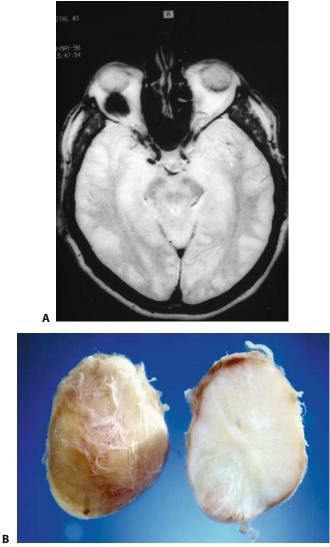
T2-weighted MR image of the orbit shows a markedly hypointense lesion (A) consistent with a hypercellular fibrous tumor, in this case solitary fibrous tumor of the right orbit (B).
